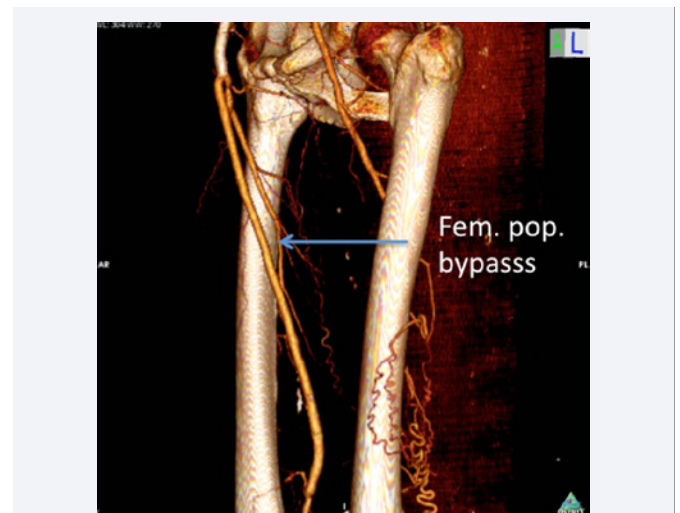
Post procedure angio CT demonstrating good result of the balloon angioplasty of the origin of the saphenous vein and a patent vein graft to the popliteal artery and no residual stenosis.
